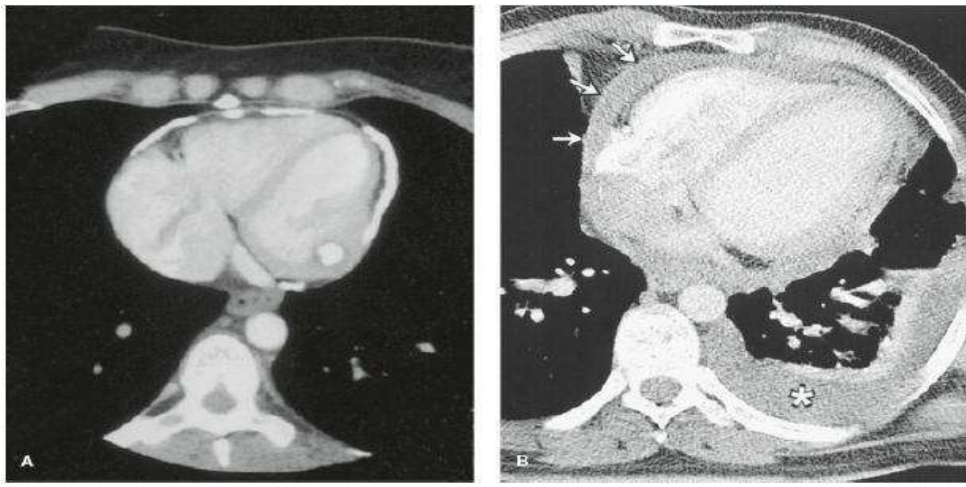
A: Chest CT shows extensive pericardial calcification. Constrictive pericarditis from a severely calcified pericardium. B: Chest CT shows thickening of the pericardium in a patient with constrictive pericarditis.
